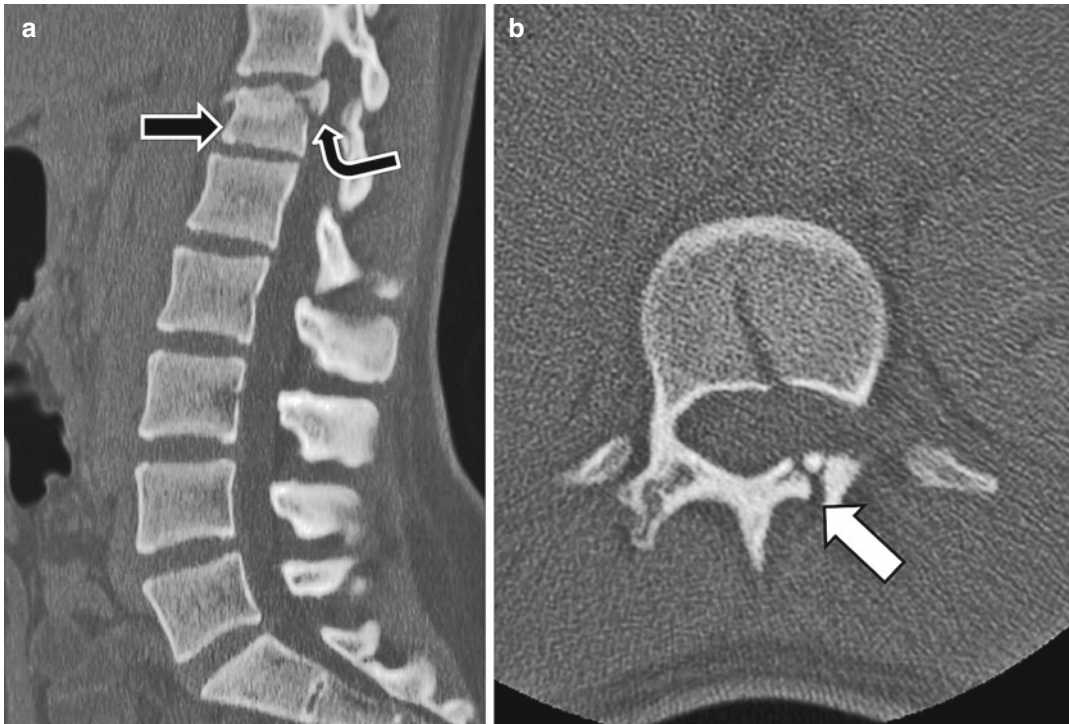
Sagittal (a) and axial (b) CT images of a T12 Chance fracture (*white arrow*) with retropulsion of the posterior vertebral body (*curved arrow*). The fracture extends through the left lamina on the axial image (*black arrow*)
